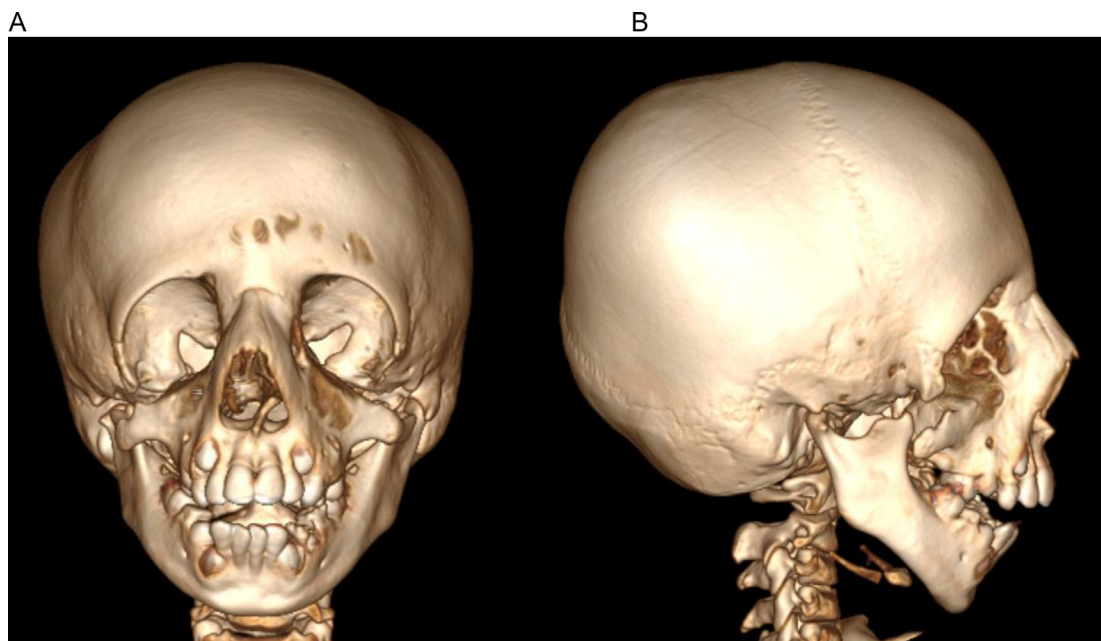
(A and B) 3D CT Volume Rendering Technique (VRT) images – Frontal and lateral views showing downward slant of the superior orbital walls, hypoplastic facial bones, hypoplastic bilateral zygoma with poorly formed zygomatic arch, micrognathia, and retrognathia. Crowded teeth are also noted in both jaws.
